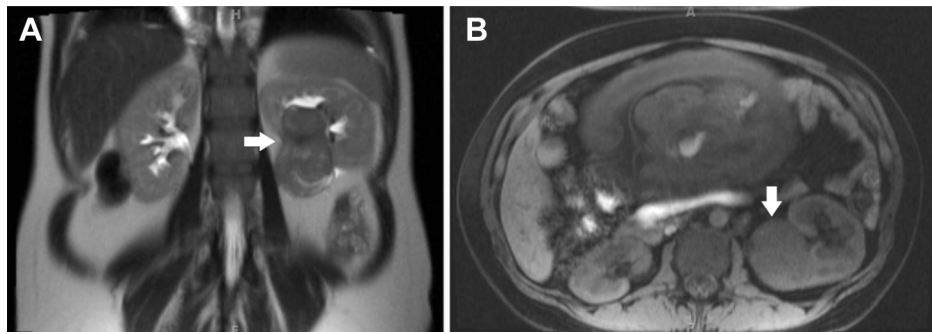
Coronal T2-weighted abdominal magnetic resonance imaging (MRI) demonstrated a large mass (arrows) in the mid and lower pole of the left kidney (A). Axial T1-weighted abdominal MRI revealed the tumor was located in the medial and posterior position and exerted a mass effect on the renal sinus without venous involvement (B).
